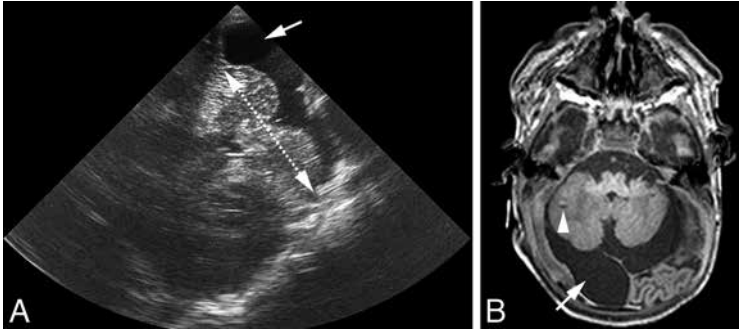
Term neonate (gestational age 40 weeks) with pyruvate dehydrogenase complex deficiency. Conventional CUS using the AF showed large bilateral germinolytic cysts (not shown). (A) CUS using right MF as acoustic window demonstrates cerebellar hypoplasia with small transcerebellar diameter of 45 mm and a possible cyst in the PF (arrow). (B) T1-weighted MRI in same neonate demonstrating cerebellar hypoplasia and an arachnoid cyst (arrow). In addition, a small punctate hemorrhage was seen in the right cerebellar hemisphere (arrowhead), not detected by CUS.
